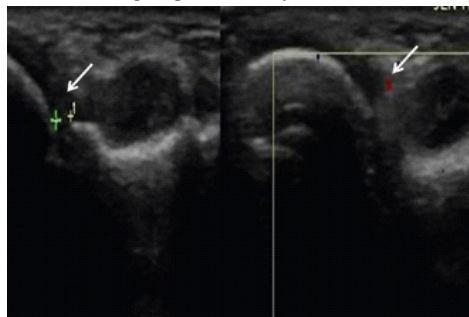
Ultrasonography shows distal radioulnar joint synovium thickened with increased vascularity
